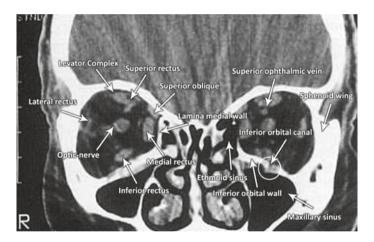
CT scan in coronal view imaged at tissue window settings
